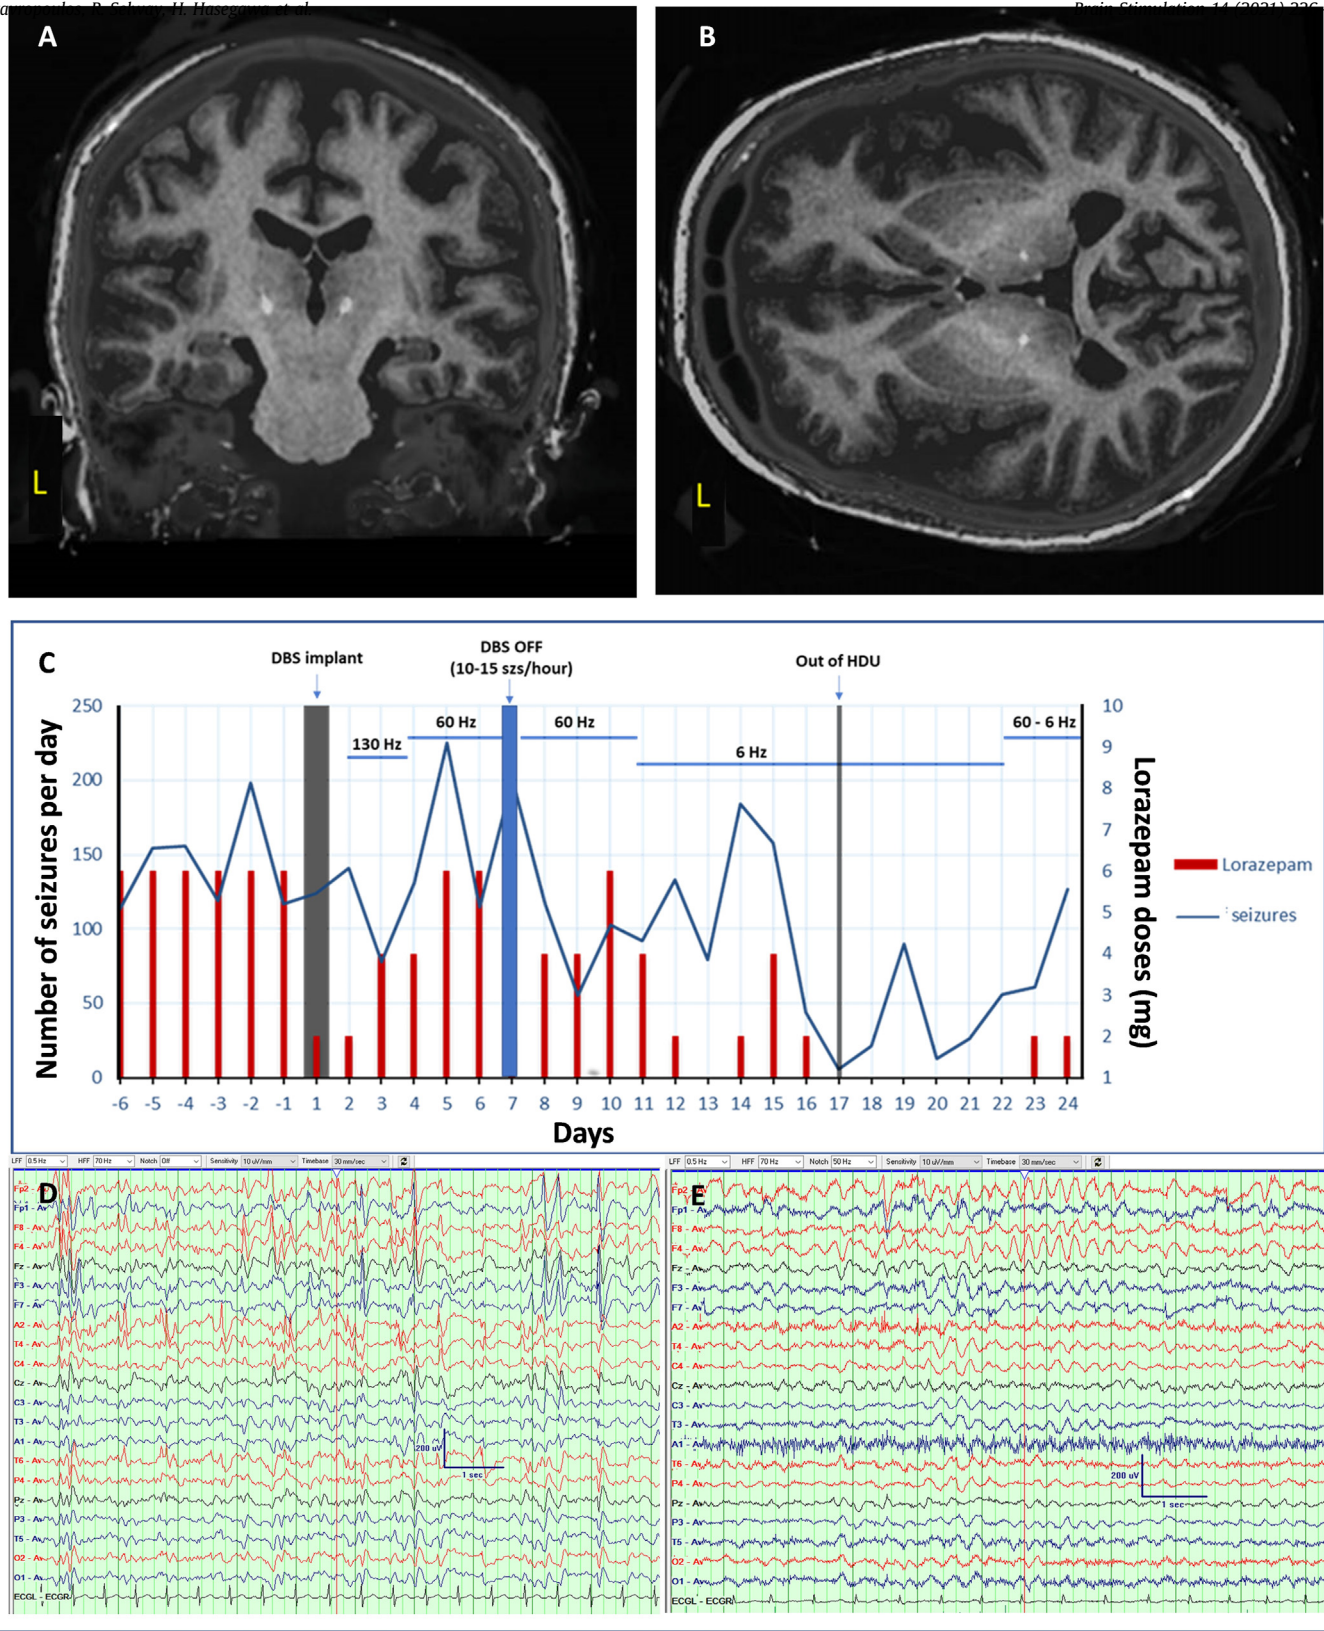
(A) Axial view of pre-implantation MRI fused with post-implantation CT; (B) coronal view of pre-implantation MRI fused with post-implantation CT showing the final position of the DBS electrodes. Note that the left DBS electrode is slightly lateral to the target, but within stimulation distance of the CMN; (C) Retrospective count of seizures by IS and DJ who were blind to treatment. Seizures were summation for every 24 hours. The different DBS stimulation parameters and the lorazepam injection for severe clinical seizures are marked through the graph. At the time of DBS implantation her medication was Melatonin, Brivaracetam, Clonazepam, Sodium Valproate and Cannabidiol. No changes in medication were done during the whole period of DBS stimulation apart from PRN lorazepam doses given for prolonged or frequent tonic clonic seizures; (D) Typical EEG recording before DBS implantation; (E) EEG recording during DBS stimulation at 6 Hz (day 16).
